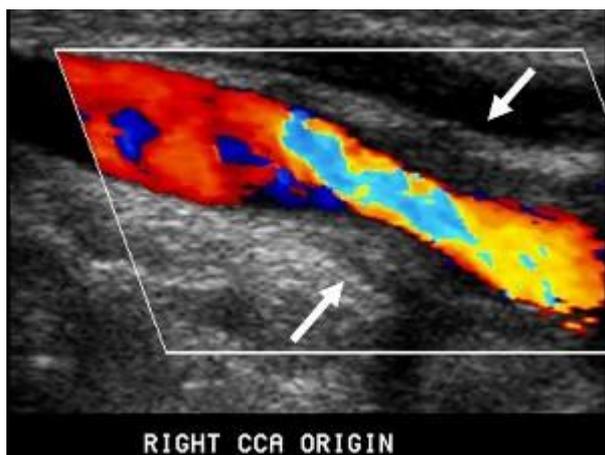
An ultrasound image of a common carotid artery in a patient with Takayasu's Arteritis.
